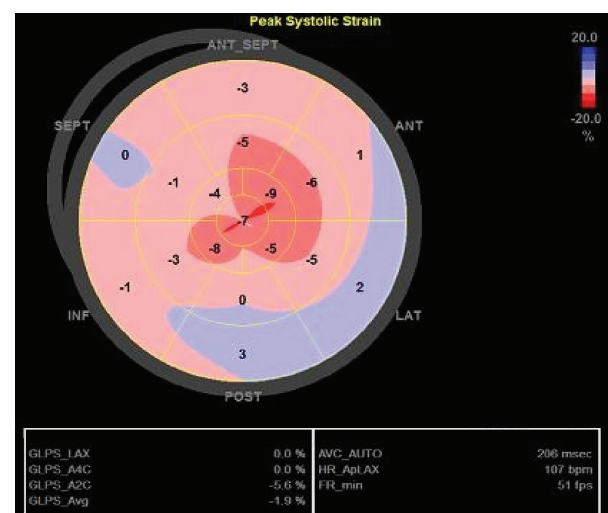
Echocardiographic speckle-tracking strain analysis showed markedly reduced global longitudinal strain (−1.9%) with relative sparing of the apex.
